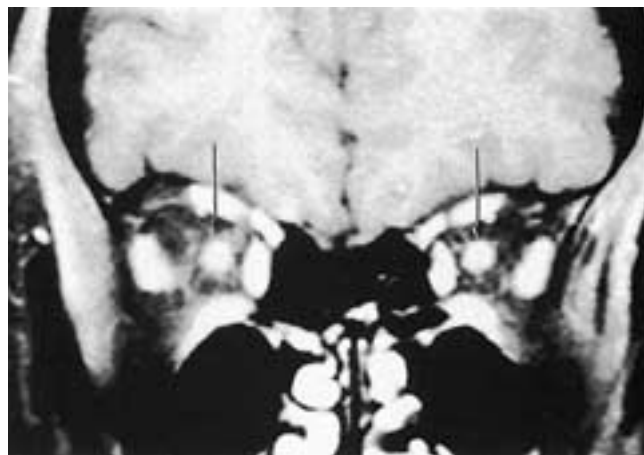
Multiple sclerosis in a 16-year-old female with bilateral scotomata and evidence of acute optic neuritis on fundoscopic examination. Coronal fat-suppressed, gadolinium-enhanced, T1-weighted MR image shows bilateral enlargement and enhancement of the intraorbital optic nerves (*arrows*).
